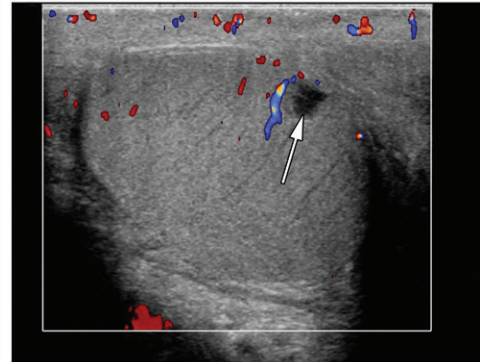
Testicular hematoma in a 29-year-old man with scrotal pain after trauma. (a, b) Gray-scale US (a) and color Doppler (b) images of the left testis show a well-circumscribed hypoechoic lesion (arrow in a) without color Doppler flow (arrow in b), compatible with testicular hematoma. (c) Color Doppler image 10 days later shows the lesion to be smaller and more hypoechoic (arrow), characteristic of testicular hematoma.
